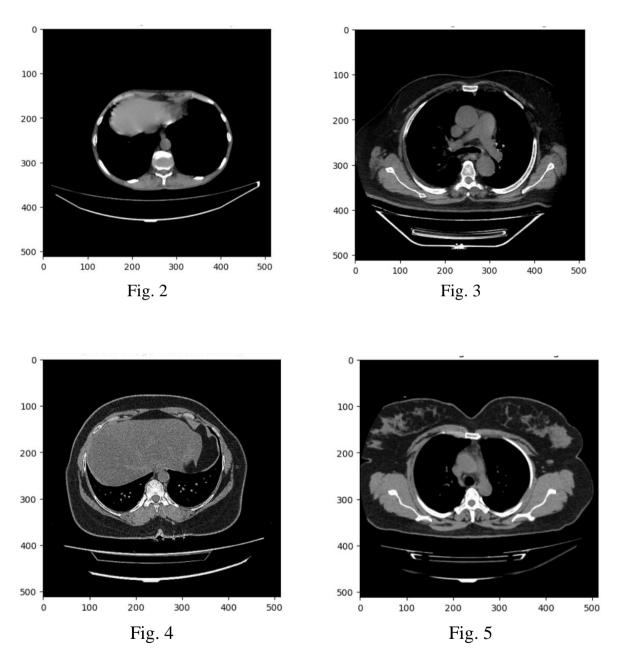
and Fig. 3 show CT scan images of COPD-affected patients, and Fig. 4 and Fig. 5 show CT scan images of normal patients.
